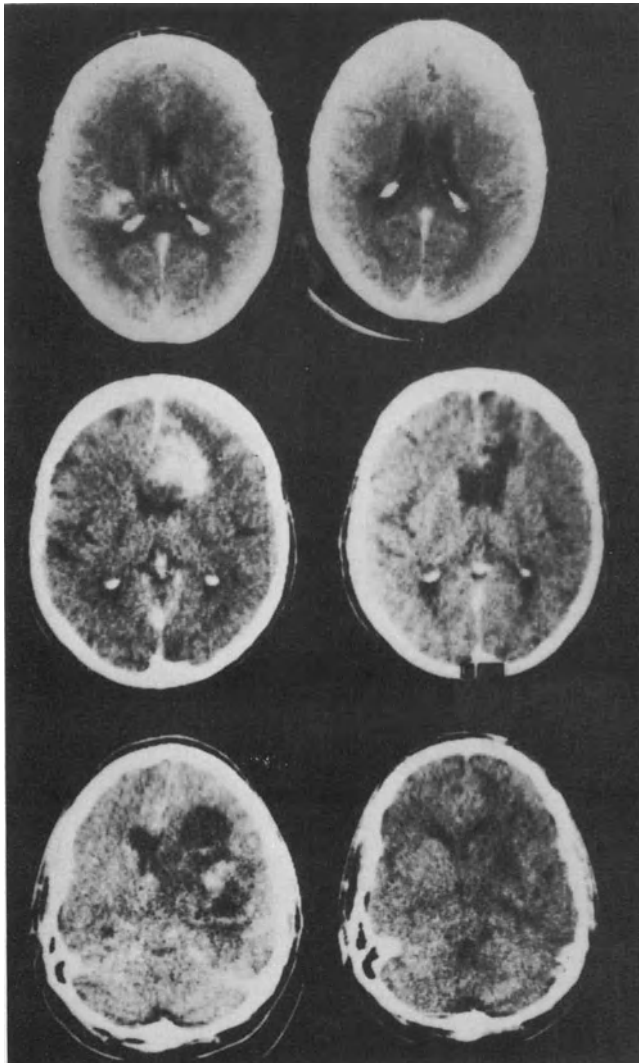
Preoperative and postoperative CT scans in three patients who underwent computer-assisted stereotactic laser resections: top—grade IV astrocytoma, deep-right parietal area; middle—grade IV astrocytoma in corpus callosum; bottom—grade III astrocytoma in basal ganglia.
